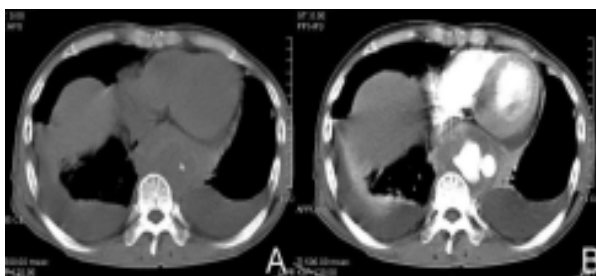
A & B. Pre-enhancing chest CT scan at aortic hiatus
